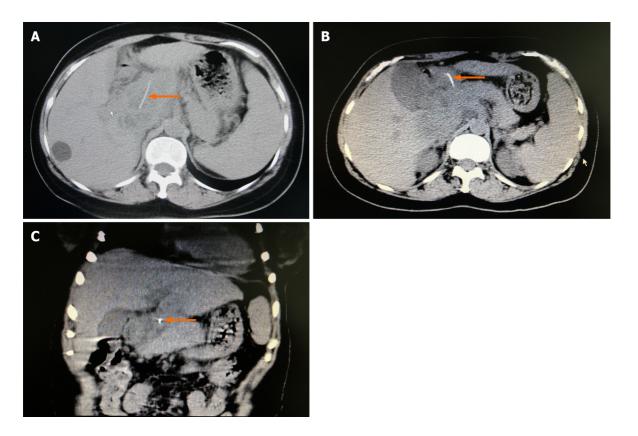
Computed tomography scan of the liver, gallbladder, and spleen. A and B: An irregular soft tissue density shadow with poorly defined borders (orange arrow) is seen above the hilum, caudate lobe, and pancreatic head. A more hypodense focus is seen inside (orange arrow), measuring about 7.8 cm × 6.0 cm × 5.0 cm. A dense shadow of about 3.7 cm in length is seen inside the lesion, the anterior end of which is located in the gastric cavity; C: A foreign body (fishbone) is seen in the upper abdomen (orange arrow) and was considered to have penetrated the gastric wall to the hepatic hilum, with an abscess having formed above the caudal lobe and pancreatic head.
